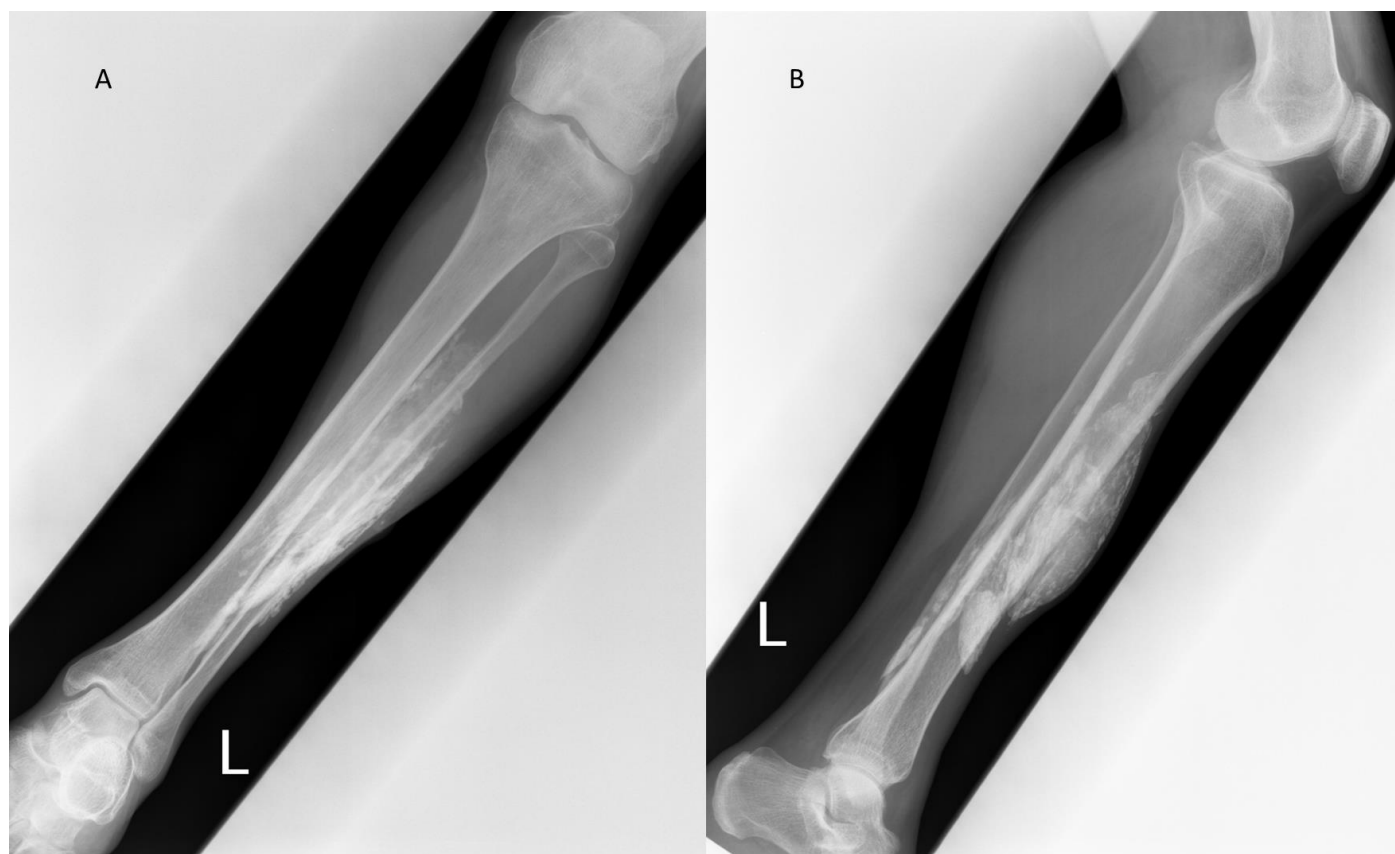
A 52-year-old male with chronic tophaceous gout. Anterior-posterior (A) and lateral (B) views of the radiograph of the left lower limb performed nine years ago. Well-defined calcification is seen centered at the anterior compartment of the left leg with no involvement of the underlying bone. Technique: Radiography.
